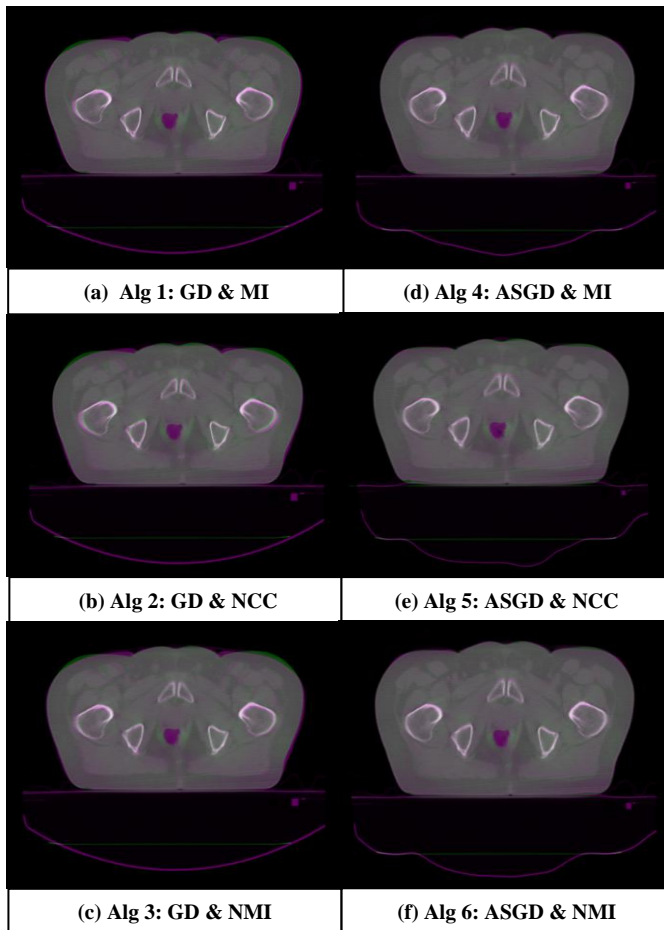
The results of superimposition of CBCT images and deformed CT images by applying six DR algorithms based on (a) GD and MI (b) GD and NCC (c) GD and NMI (d) ASGD and MI (e) ASGD and NCC (f) ASGD and NMI.
